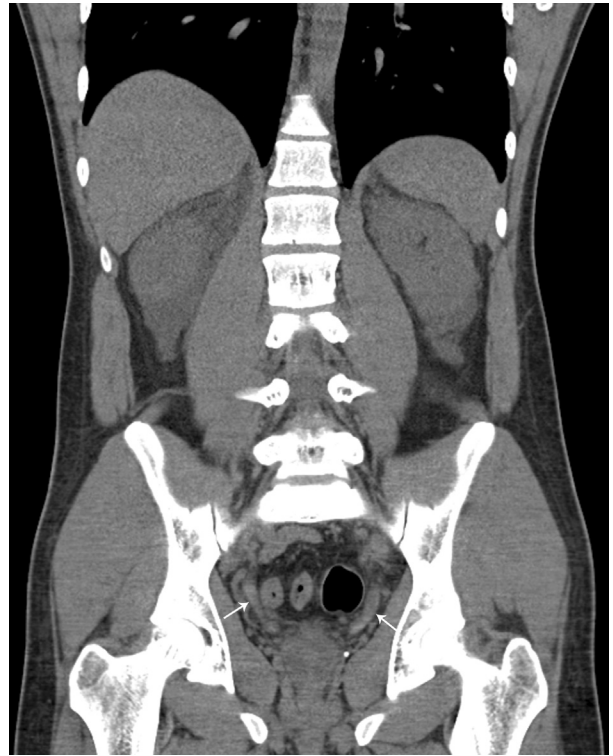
Computed tomography scan of the abdomen and pelvis without i.v. contrast demonstrating hyperdense material in the distal aspects of both ureters (denoted by arrows).
